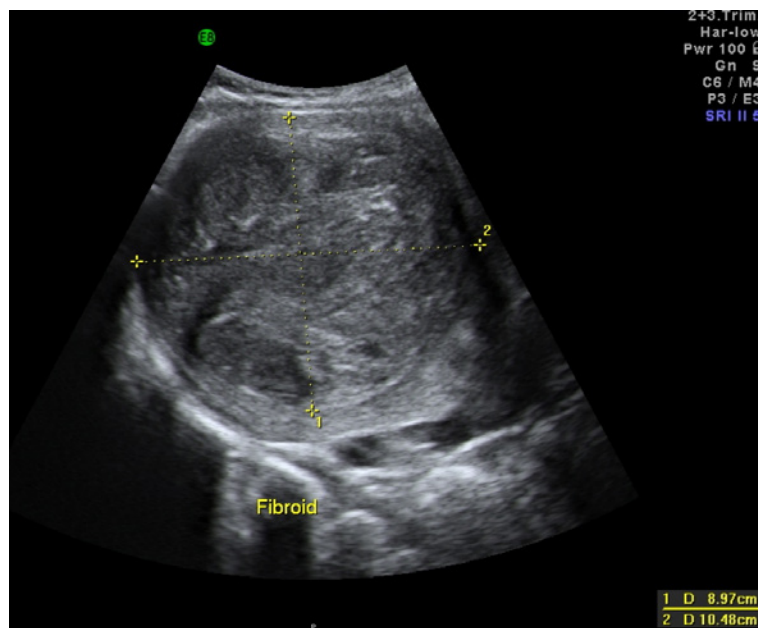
Ultrasound showing a uterine fibroid with its edges well defined
